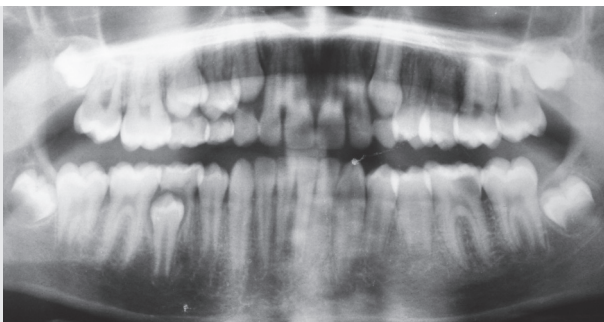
Preoperative situation: The lesion in tooth 36 is clearly visible on the X-ray. The remaining mixed dentition is caries free.
